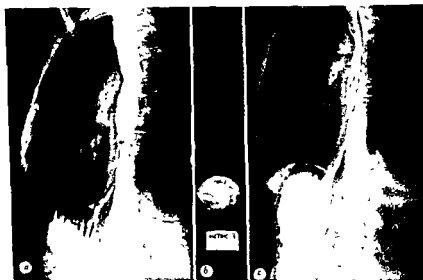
Stricture of the esophagus which followed typhoid fever; a foreign body is lodged in the stricture. At the time of roentgenologic examination of the esophagus this was thought to be due to tumor. *b*, Esophagoscopy revealed a plum pit, which was removed. *c*, The esophagus after removal of the foreign body and esophageal dilation.
